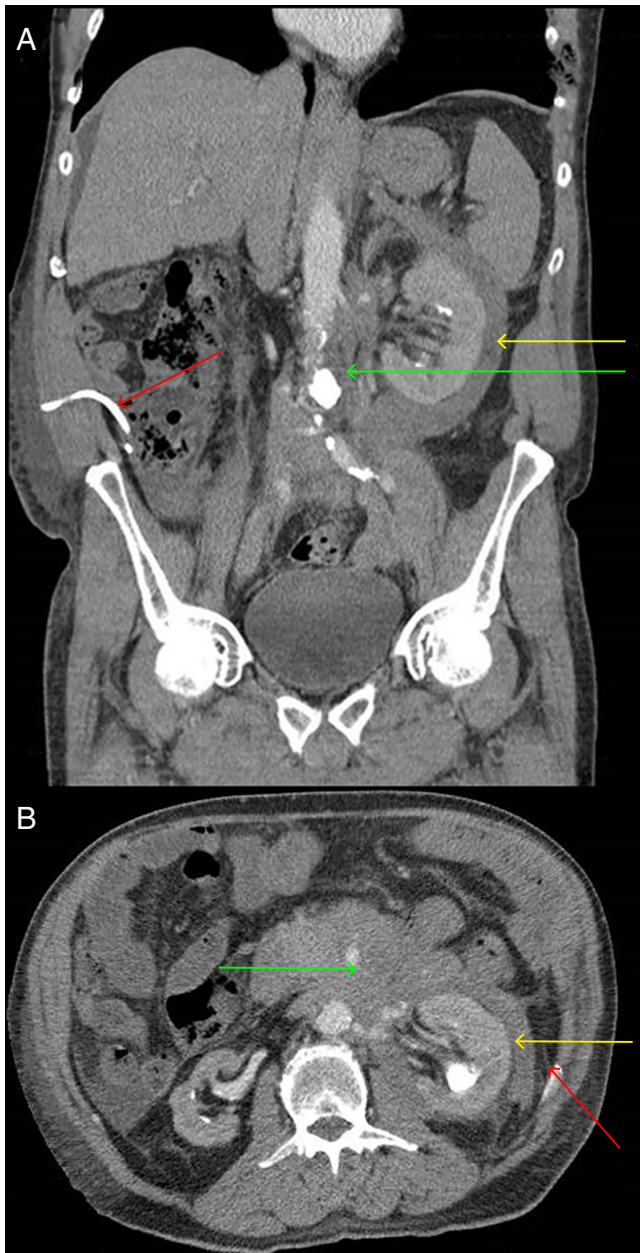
(A) Abdominal and (B) pelvic computed tomography confirming a retroperitoneal mass encasing the main abdominal vessels-mesenteric. Noted on the images are the renal and upper abdominal aorta (green arrow), the residual ascites with pigtail in situ (red arrow), and hydronephrosis with some ureteric obstruction (yellow arrow).
